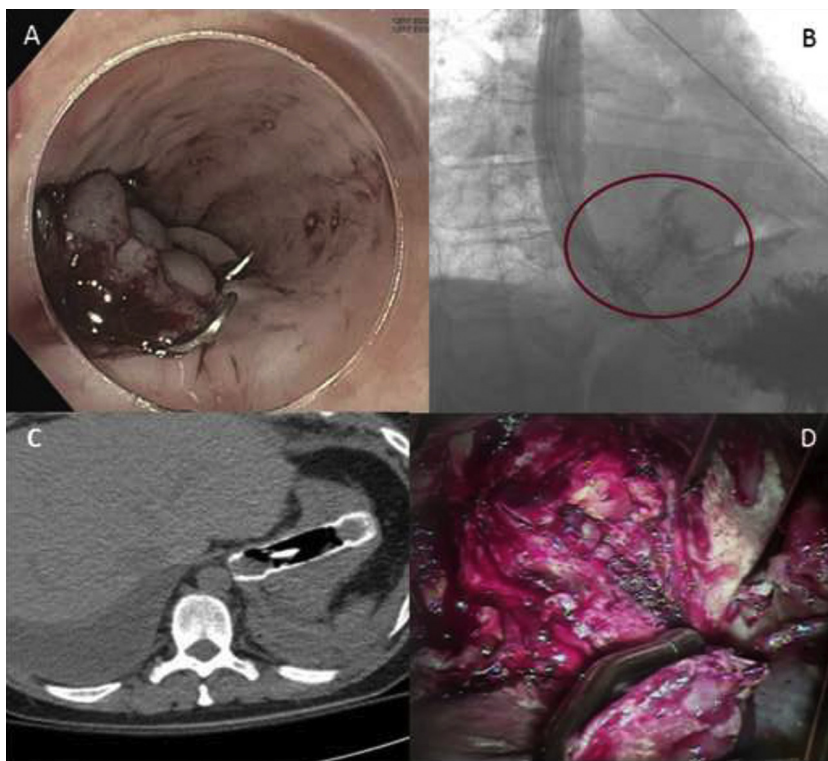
Pre-operative endoscopic and radiological findings. 1A: Endoscopic image demonstrating esophageal tear with two over the scope clips (OTSC). 1B: Esophagram showing persistent esophageal leak. Fig. 1C: CT scan showing esophageal stent migration into the stomach 1D: Primary repair of mucosal and muscular esophageal layers.
